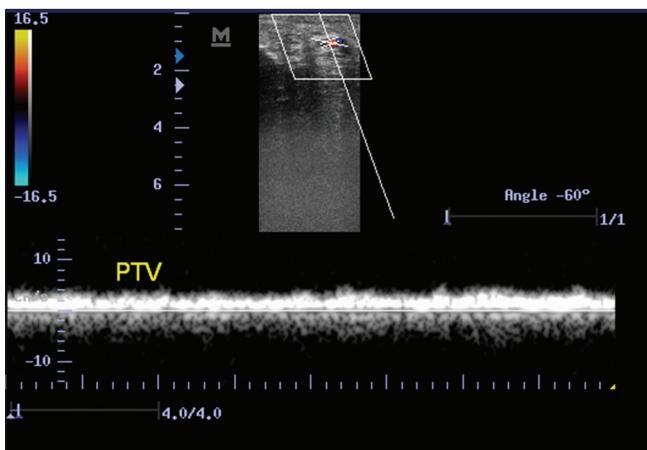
A spectral Doppler sonogram of the posterior tibial vein in a patient with partial femoro-popliteal thrombosis showing the absence of respiratory variation
